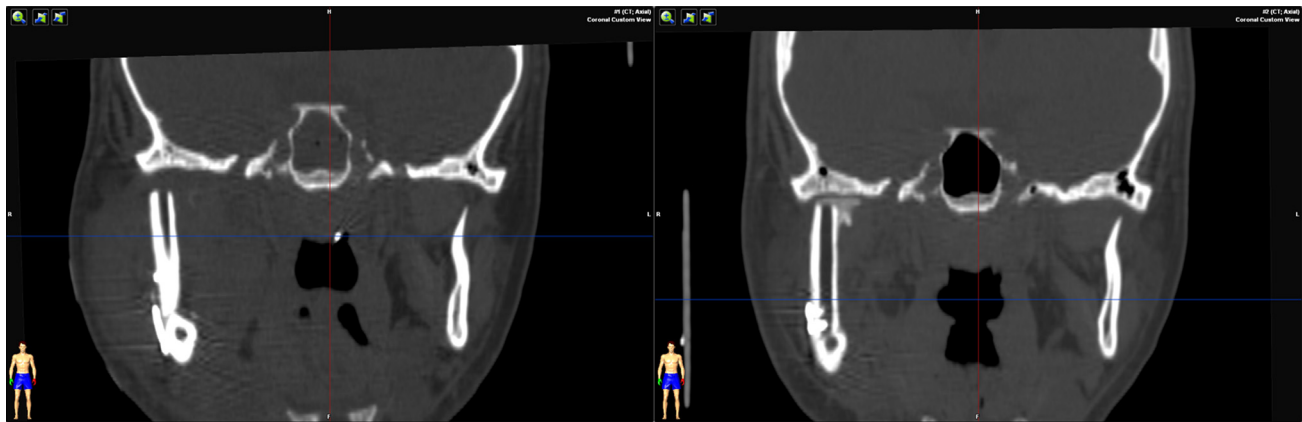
Compared with the 1-month postoperative CT examination (left), the 3-month postoperative CT shows neocondyle bone growth (right).
